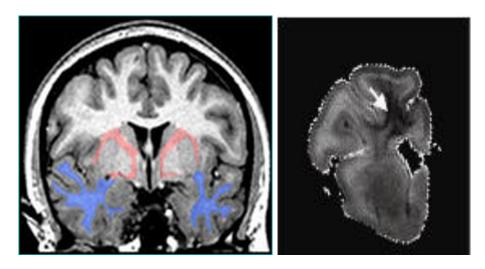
This MRI shows regions where white matter volumes were significantly reduced in boys born preterm. Blue marks the temporal lobe and red the deep cerebral region (*Michelle*, 2004).
